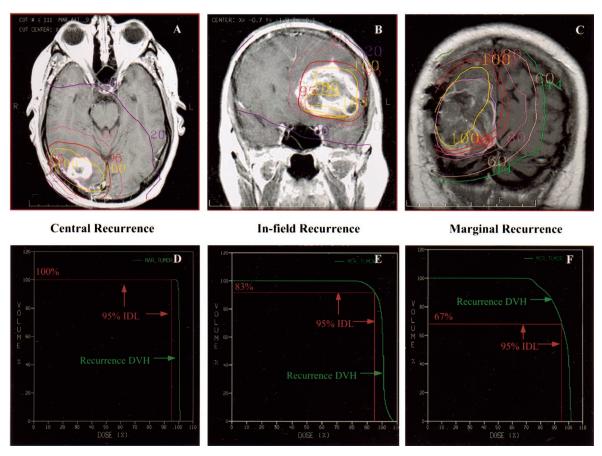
(A, B, C) Examples of tumor recurrences on T1-weighted MRI scans superimposed with original treatment isodose lines. (D, E, F) Corresponding DVHs demonstrating the percentage of recurrent tumor within the 95% IDL (see text).
